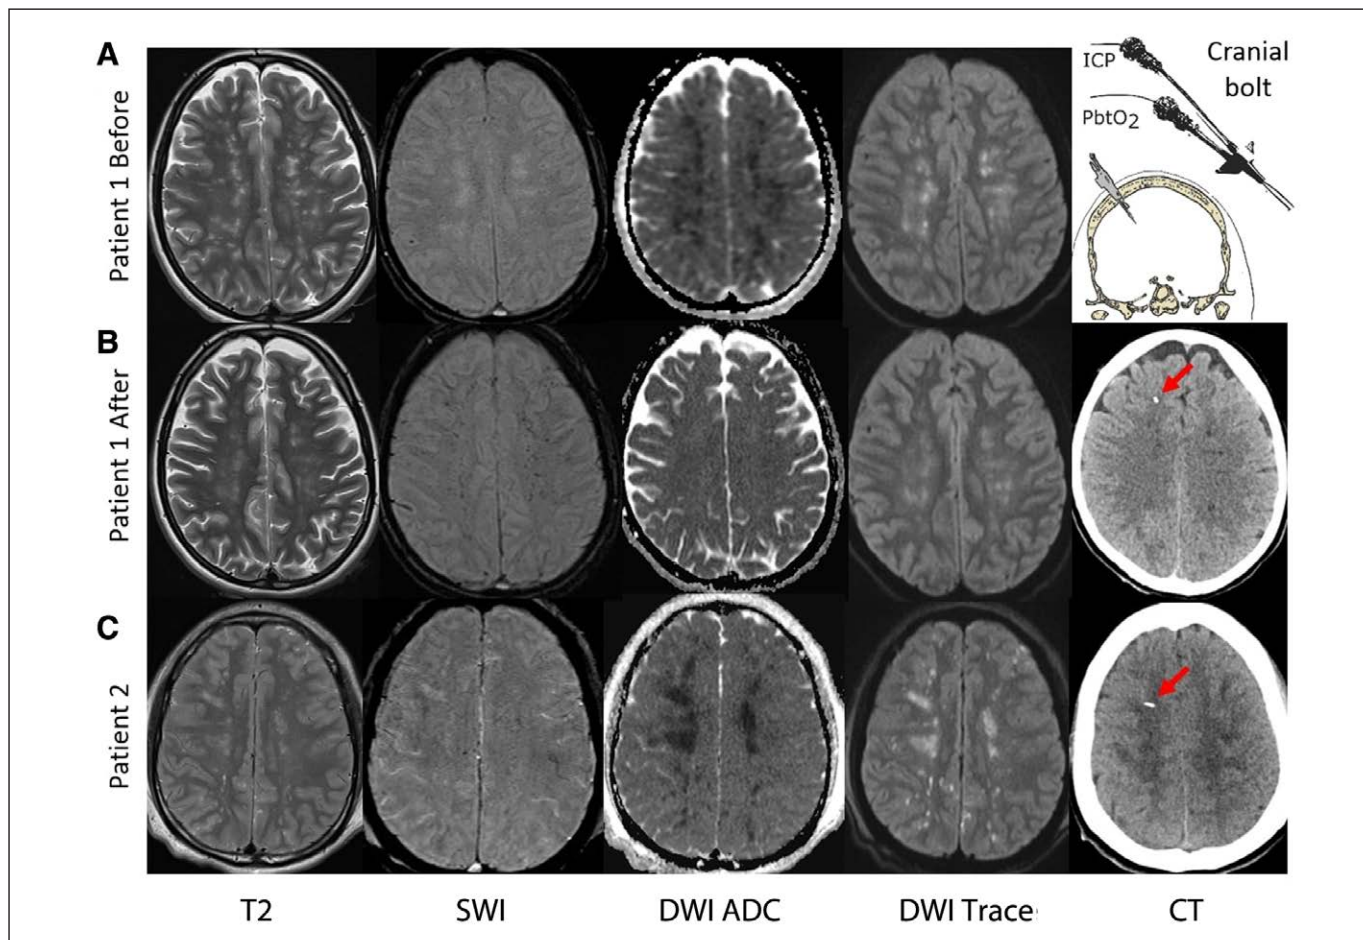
Neuroimaging from both patients including (from left to right), the axial images for MRI sequences pertaining to T2, SWI, apparent diffusion coefficient (ADC), and diffusion-weighted imaging (DWI) are shown. Collectively, the images in (A) reflect bilateral subcortical restricted diffusion (ADC and DWI), reflecting possible tissue ischemia in the setting of fat embolism syndrome. Bilateral diffuse punctate hemorrhages are shown on SWI imaging. In patient 1 and 2, the tip of the brain tissue oxygenation (Pbto₂) catheter was confirmed within the tissue region of the MRI confirmed restricted diffusion (denoted by the red arrow on noncontrast CT, rightmost image in [B]). B, MRI sequences following goal-oriented management guided by invasive neuromonitoring and after removal of the invasive neuromonitoring days after initiation. The follow-up ADC and DWI sequences reveal partial resolution of the restricted diffusion after neuromonitoring guided care. The SWI sequence does not demonstrate new or increased punctate hemorrhages. C, MRI sequences pertaining to T2, SWI, ADC, and DWI images revealing bilateral subcortical white matter restricted diffusion (ADC and DWI) and punctate hemorrhages (SWI) in patient 2. ICP = intracranial pressure, SWI = susceptibility weighted imaging.
